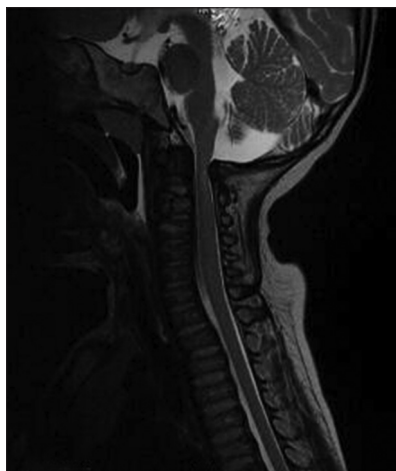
MRI of the child showing cervical cord compression
